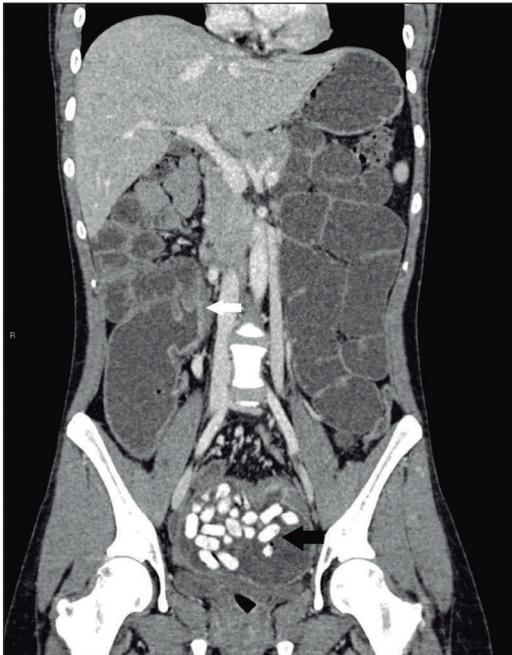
MPR coronal reconstruction of CT enterography. Wall thickening and mucosal hyper-enhancement of a portion of the medium ileum (white arrow). Non-absorbed mesalazine pills inside a dilated loop of ileum (black arrow).
